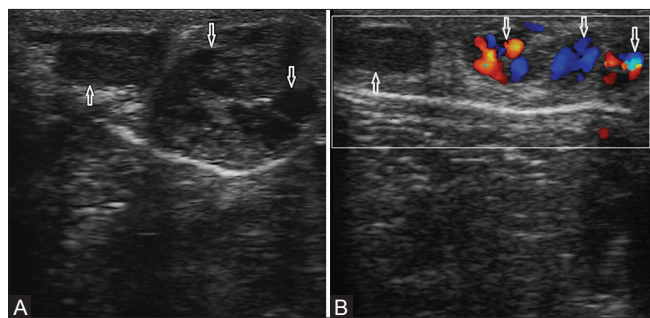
(A and B): (A) Gray-scale sonogram of the left scrotum showing multiple, dilated, tortuous/serpiginous, hypoechoic, tubular structures (downward arrows); the left testis with its mediastinum is sonographically normal (upward arrows). (B) Duplex sonogram of the left scrotum showing florid vascularity of the hypoechoic tubular structures on color Doppler insonation (downward arrows)
